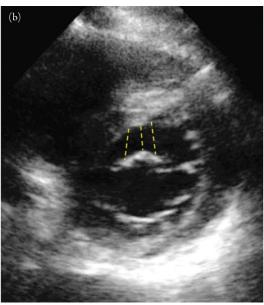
(a) E-point septal separation (EPSS) measured proximal to the mitral leaflet tip. This measurement leads to an increased EPSS measurement and underestimation of left ventricular systolic function. (b) E-point septal separation (EPSS) measurements as shown on parasternal short axis window. Note that the central plane gives a smaller EPSS than the medial or lateral planes. A parasternal long axis plane that is too medial or lateral will underestimate the left ventricular systolic function.
